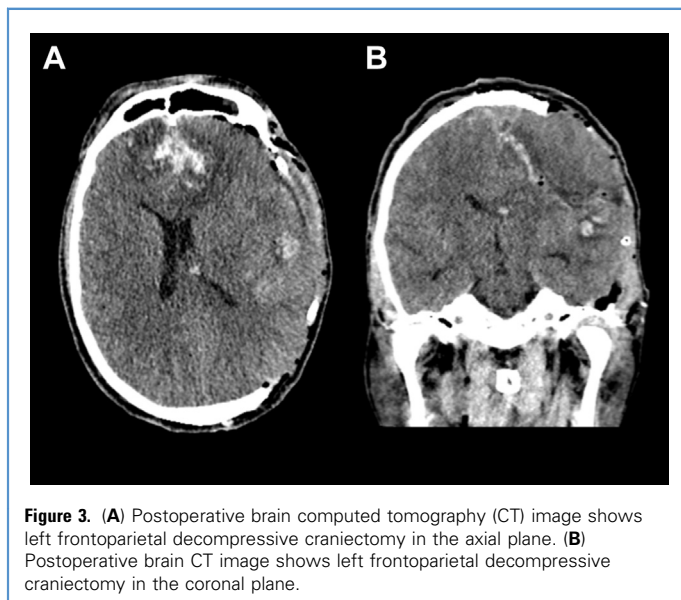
(A) Postoperative brain computed tomography (CT) image shows left frontoparietal decompressive craniectomy in the axial plane. (B) Postoperative brain CT image shows left frontoparietal decompressive craniectomy in the coronal plane.
